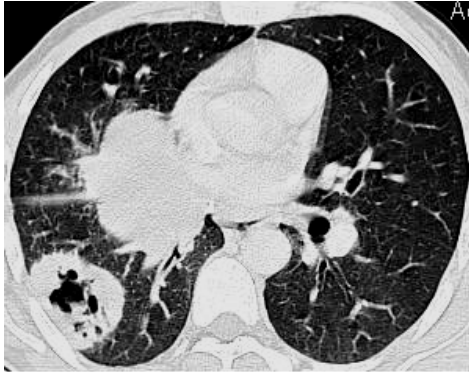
Axial CT, lung window at the level of left atrium shows thick walled cavity with permeating spiculated margins at lower lobe of right lung associated with right bronchopulmonary lymphadenopathy proved to be bronchial carcinoma.
